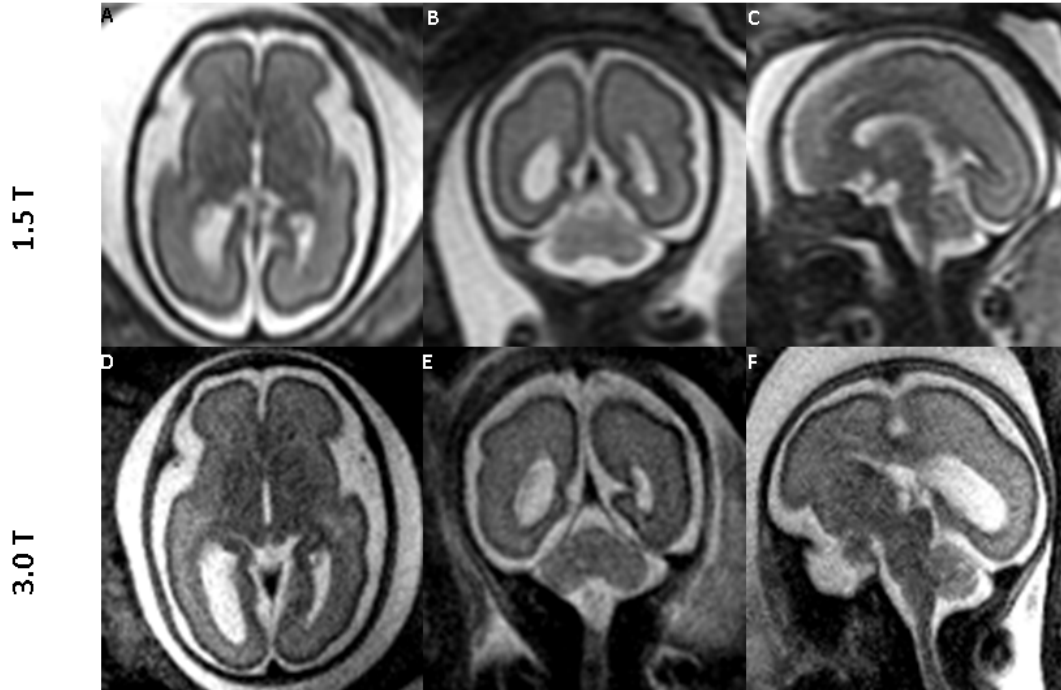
Comparing images of the fetal brain at 26 weeks of gestation obtained at 1.5T and 3.0T MRI (same fetus): 1.5T (top row, A-C) and 3.0T (bottom row, D-F) in all three orientations: Axial (A,D); Sagittal (B,E); and Coronal (C,F). Both 1.5T and 3.0T scans were performed on the same day. The images from 3.0T show superior tissue contrast and conspicuity to that of 1.5T.
